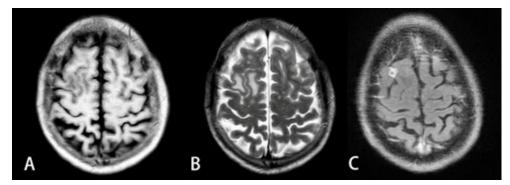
MRI Images of a Case of Neuroblastoma (NB) Resulting in Right Frontal Lobe Brain Abscess. A: T1-weighted image showing a low-signal lesion in the right frontal lobe. B: T2-weighted image displaying a high-signal lesion in the right frontal lobe. C: Enhanced T1-weighted image revealing a ring-enhancing lesion in the right frontal lobe.
